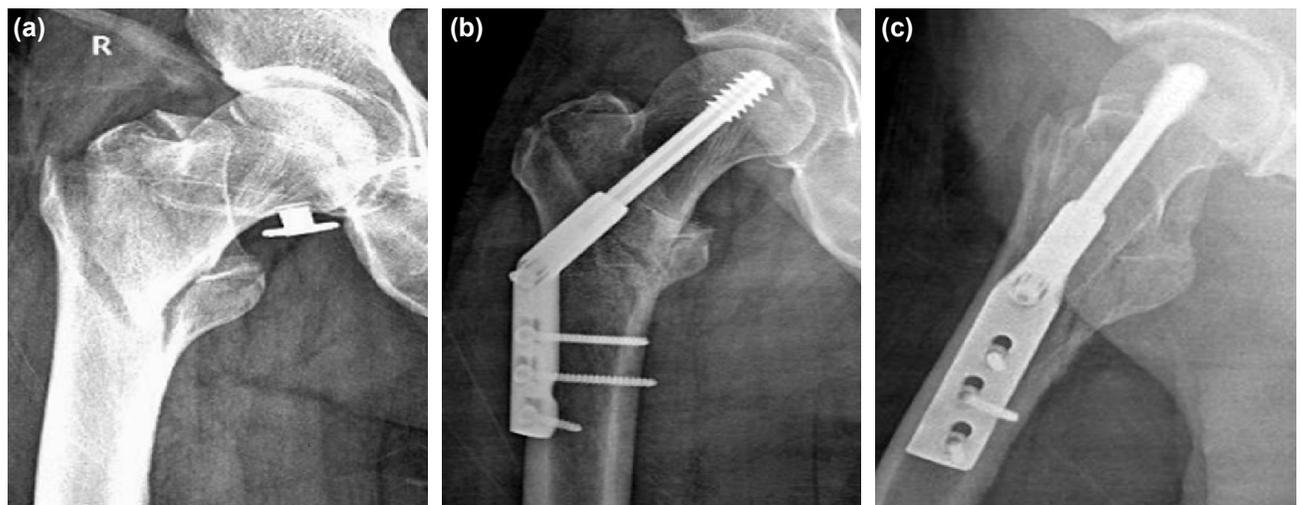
(a) Anteroposterior radiograph of a 56 years old man with an A1 type intertrochanteric femur fracture. (b) Postoperative anteroposterior radiograph of the fracture treated with DHS. (c) Postoperative lateral radiograph of the fracture treated with DHS.
